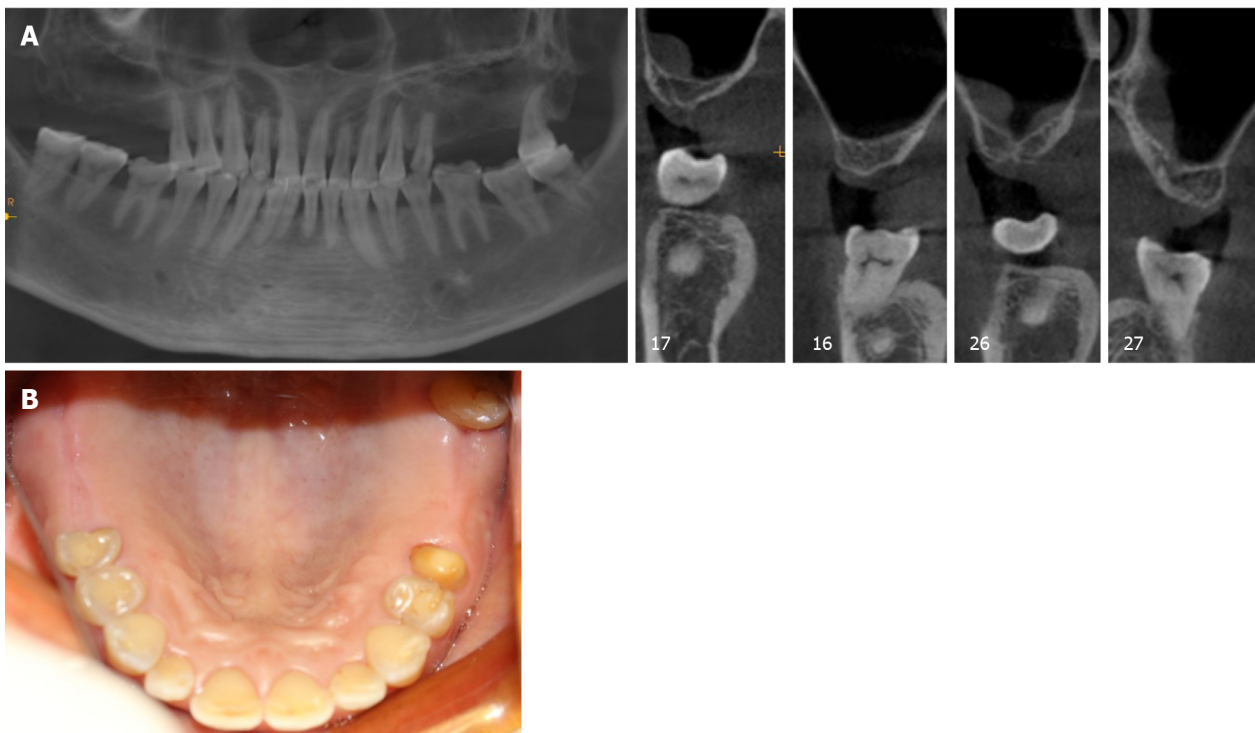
Preoperative cone-beam computed tomography and intraoral photograph. A: Preoperative cone-beam computed tomography; B: Intraoral photograph.
